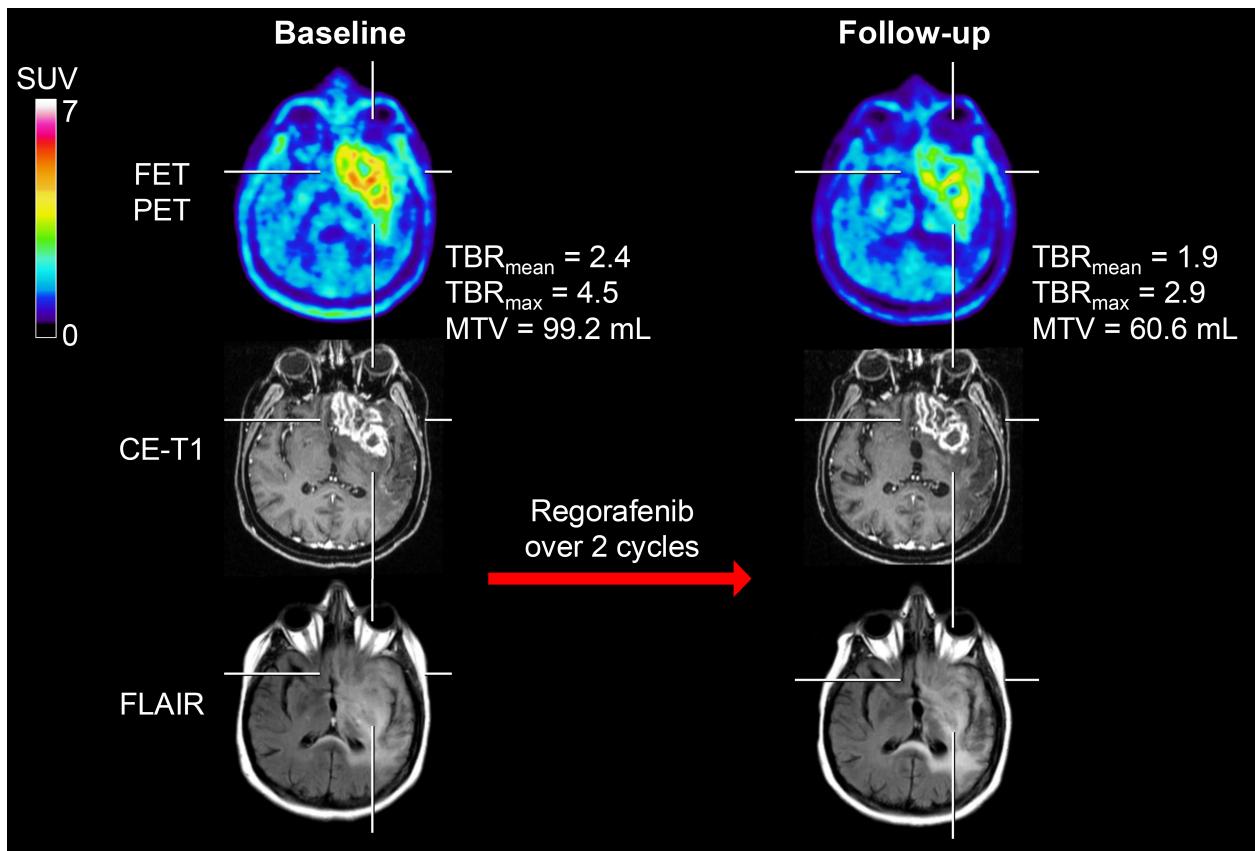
MRI and FET PET of a 44-year-old glioblastoma patient (patient #6) at baseline and after 2 cycles of regorafenib. Following regorafenib, FET PET at follow-up revealed a substantial reduction of metabolic activity compared to the baseline scan, i.e., a decrease of TBR_{mean} by 21%, TBR_{max} by 36%, and MTV by 39%, also fulfilling the criteria for a PET-based *Partial Response* according to the PET RANO 1.0 criteria. In contrast, the contrast-enhancing lesion on MRI remained unchanged. The patient received eight regorafenib cycles and had a favorable overall survival of 27 months after initiation of regorafenib.
